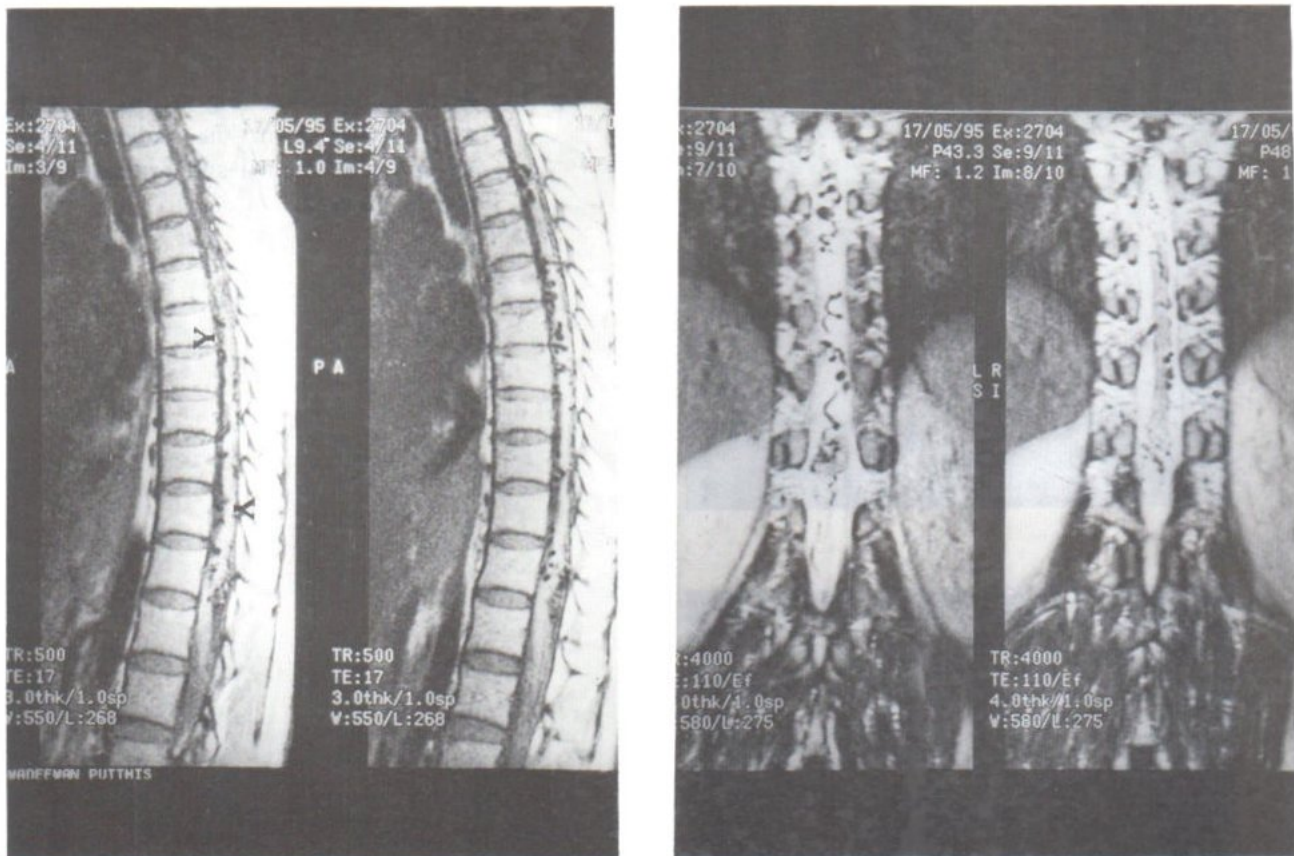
MRI in sagittal and coronal view showed serpiginous flow void tubular structures along ventral and dorsal aspect of the cord down to conus medullaris (arrows).
